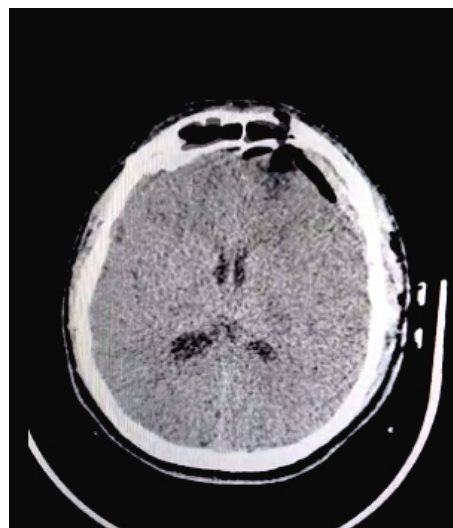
Non-contrast CT of the head showing post traumatic fracture of both walls of frontal air sinus with extension of pneumocephalus into frontal lobe compressing frontal lobe *i.e.* tension pneumocephalus.
